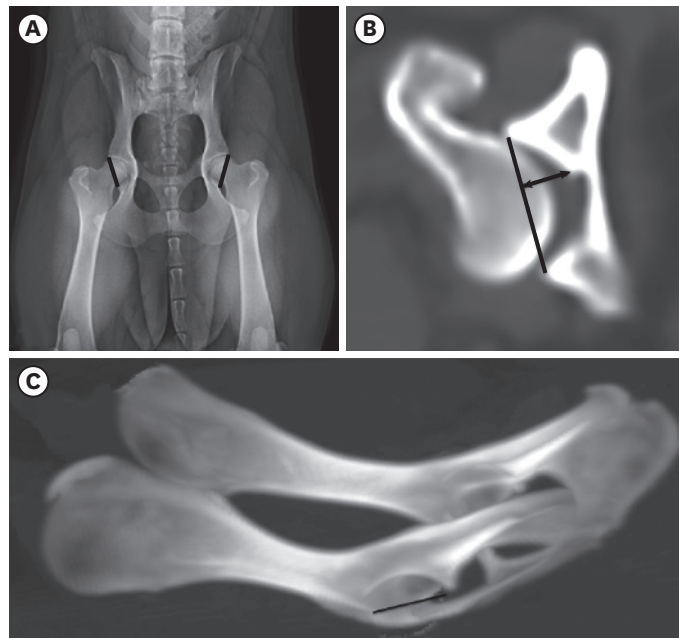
Acetabular parameter measurement methods. Acetabular widths were measured in a craniocaudal direction on radiographs (A), in a craniolateral-ventrolateral direction on 2D-CT images (B), and in a craniocaudal direction on 3D-CT images (C). Acetabular depth (arrow) was measured on two-dimensional computed tomographic (CT) images (B) from the medial edge of the sourcil to the line between the lateral edge of the dorsal acetabular rim. D, dimensional; CT, computed tomography.
